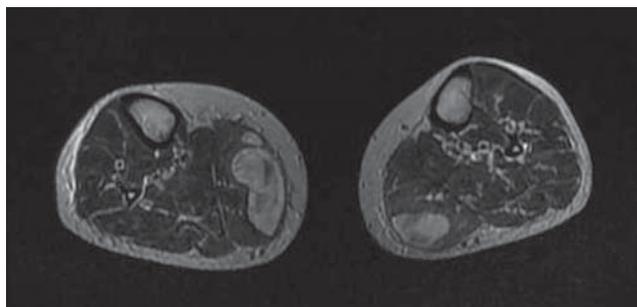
Contrast-enhanced MRI of the calves (axial view): bilateral Baker's cysts containing scratchy material, probably bleeding.
